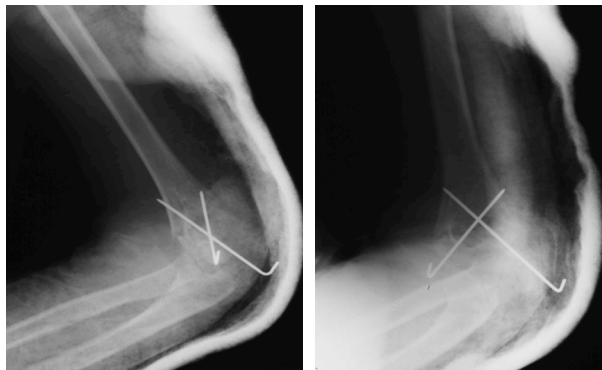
a and b. *Postoperative radiographs after open repositioning of supracondylar with the stabilization with "K" wires.*
